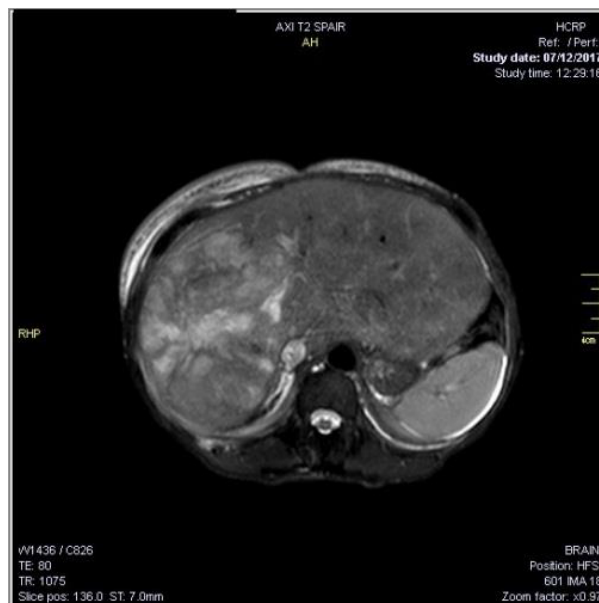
Magnetic resonance of the abdomen: T2-weighted axial cut. Hyperintense mass in the hepatic segments VII and VIII.
